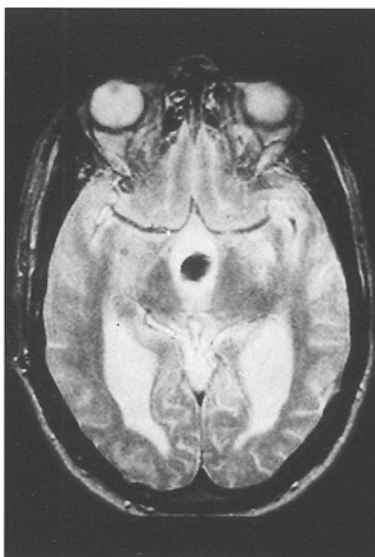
Brain MRI; T2-weighted image showing a rounded hypointense lesion in the third ventricle, consistent with a colloid cyst
